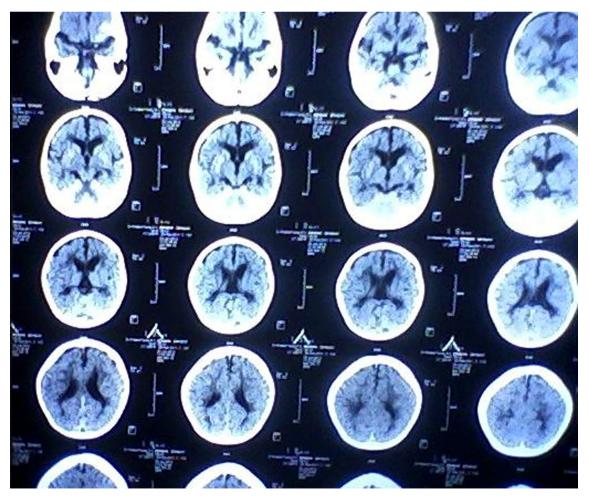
CT brain findings of one case showing diffuse brain atrophy.
